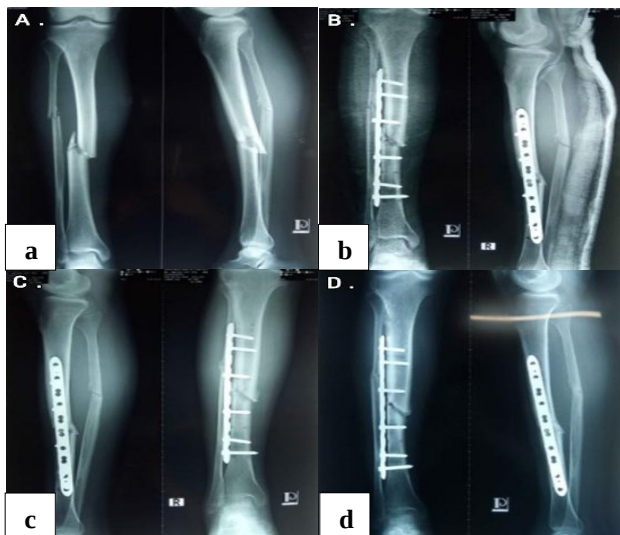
Pre-operative and follow up X-rays (a) pre-operative X-ray, (b) immediate post-operative X-ray, (c) X-ray after 6 weeks, and (d) X-ray after 24 weeks.
